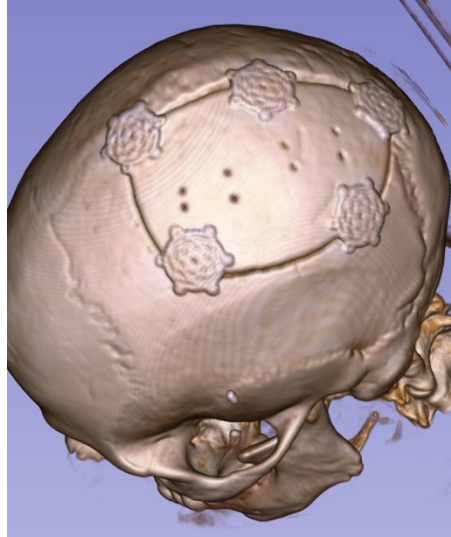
3D view of the high CT number tissues and materials such as bone and Ti implants for patient B1. This patient had five Ti implants on the left parietal bone.
